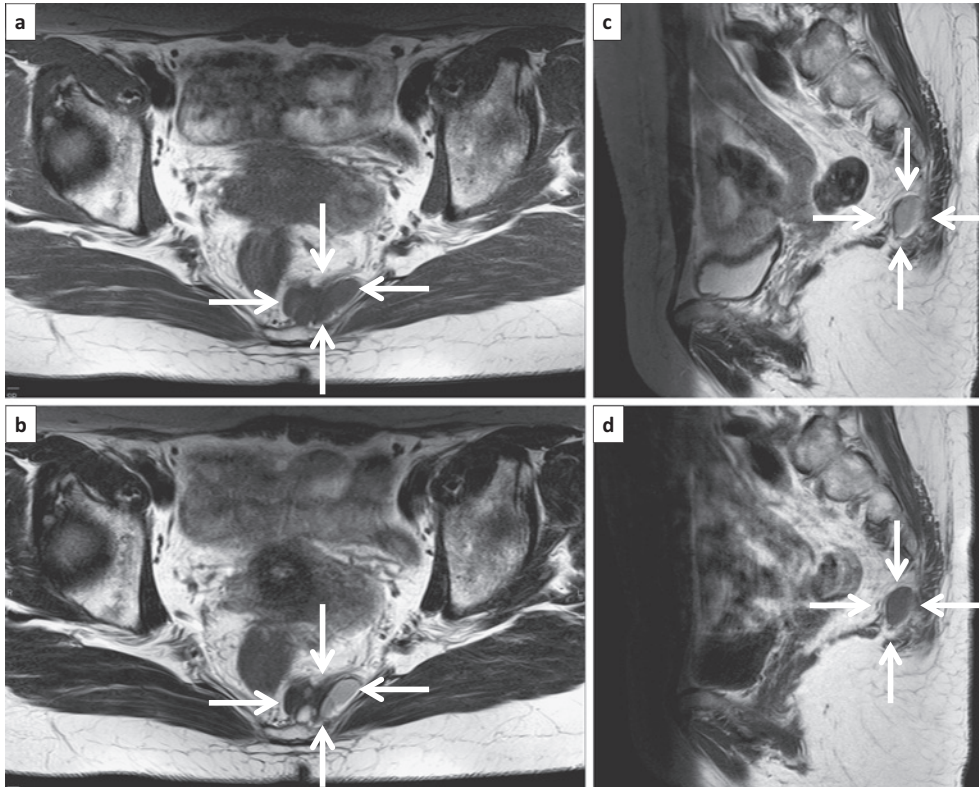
MRI showing the cystic mass approximately anterior to the coccyx. The cyst contents were a combination of low-signal intensity on T1WI (a and c, white arrows) and high-to-low signal on T2WI (b and d, white arrows).
